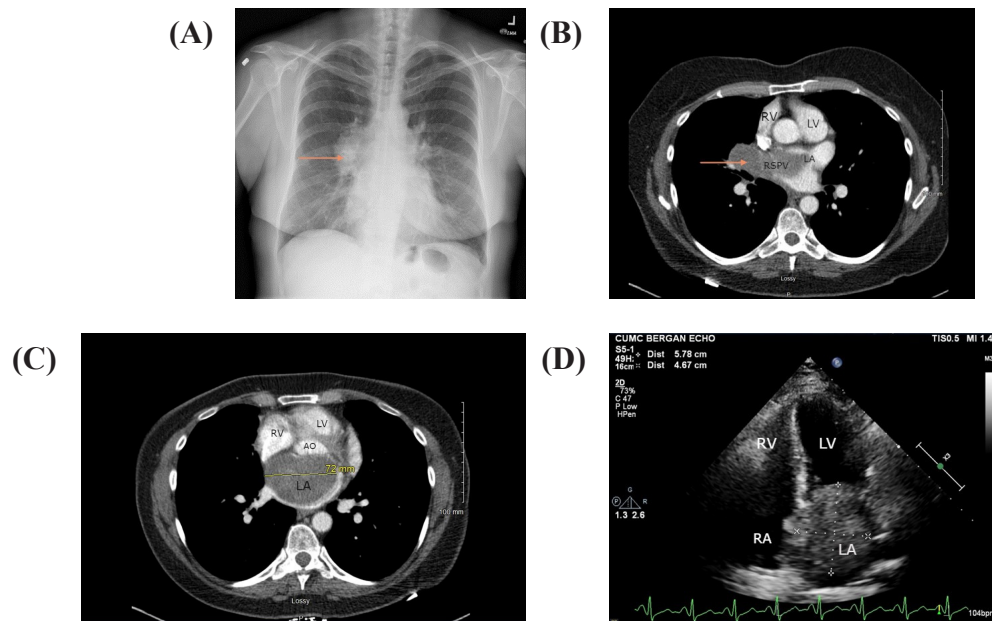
(A) Chest X-ray posteroanterior view showing a right hilar mass/adenopathy; (B) CT chest showing right hilar mass (arrow) extending through the right superior pulmonary vein into the left atrium; (C) CT chest showing large left atrial mass (dotted line); (D) Transthoracic Echocardiogram apical 4 chamber view, the dotted line showing the size of large mass noted in the left atrium. LA: left atrium; RA: right atrium; LV: left ventricle; RV: right ventricle; RSPV: right superior pulmonary vein.
